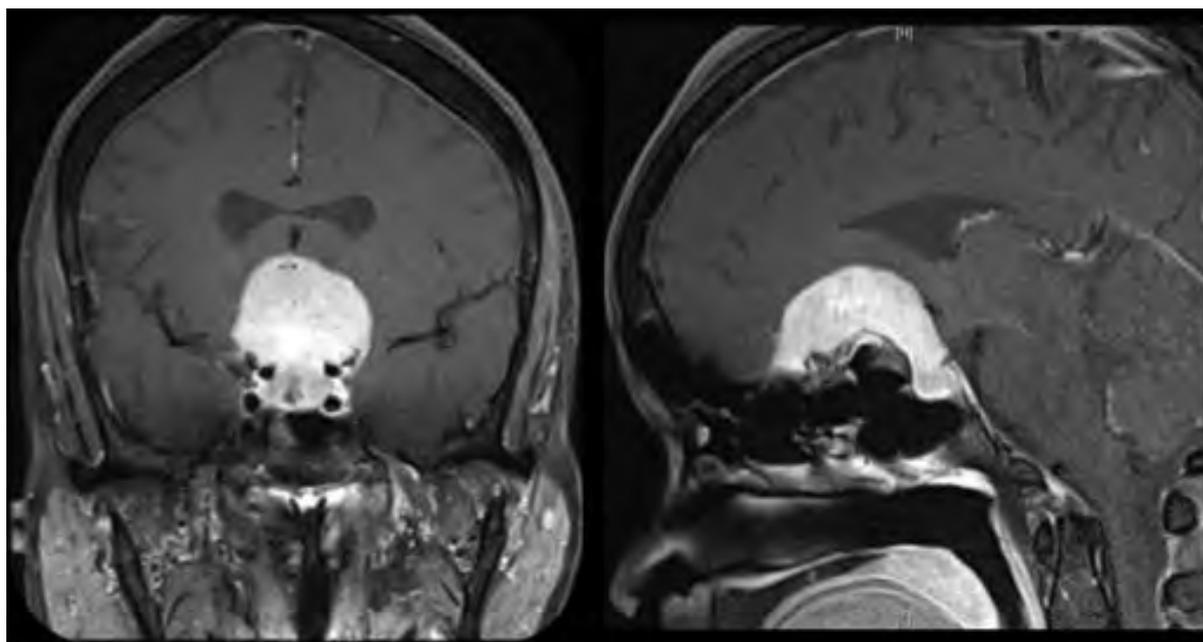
A 37-year-old woman, with an estimated gestational age of 37 weeks, presented to our hospital with protracted headaches and bilateral, nonpostural visual blurring. Neurologic examination was remarkable for anosmia, no light perception OS, 20/20 visual acuity OD, pale disc OS, blurred nasal margins of the OD, and a left relative afferent pupillary defect (APD). T1-weighted, postcontrast, MRI of the brain (coronal and sagittal views) obtained post delivery, demonstrate an avidly enhancing extra-axial mass lesion arising from the region of the planum sphenoidale and fovea ethmoidalis with posterior extension to the suprasellar cistern and inferior extension to contact the pituitary gland. There is a suggestion of encasement of the left optic nerve and partial encasement of the right optic nerve. The lesion abuts the supraclinoid carotid arteries but without obvious encasement. Surgical pathology corroborated an olfactory groove meningioma (WHO Grade 1). The tumor was positive for progesterone receptors and the Ki-67 proliferation index overall is less than 1%.
